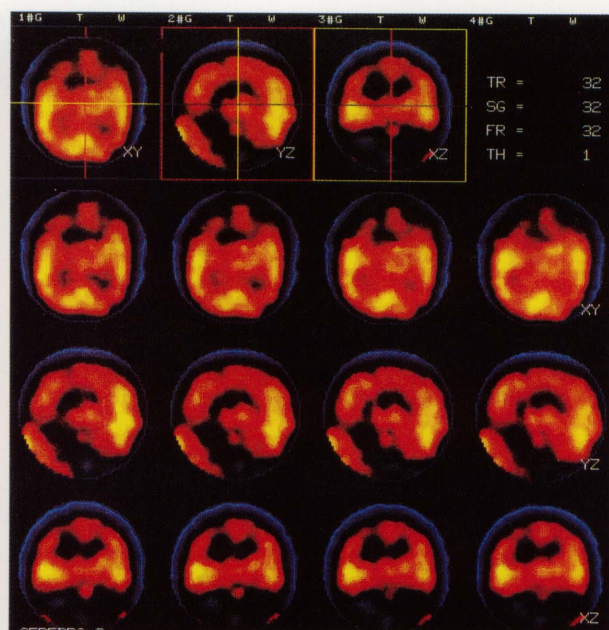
^{99m}Tc -HMPAO SPECT carried out during an ictal phase showing increase in signal in the anterior, mesial and lateral aspects of the left temporal lobe (Patient no. 8).
